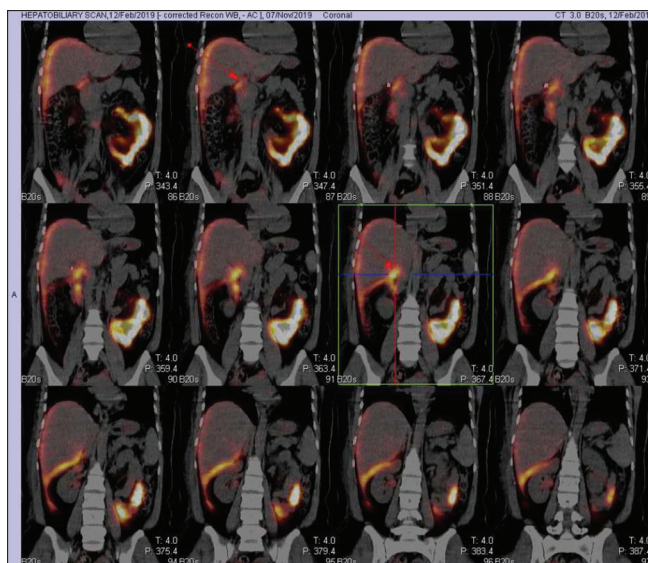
Hepatobiliary scintigraphy single-photon emission computed tomography/computed tomography fusion images showing site of the biliary leak (arrows)
